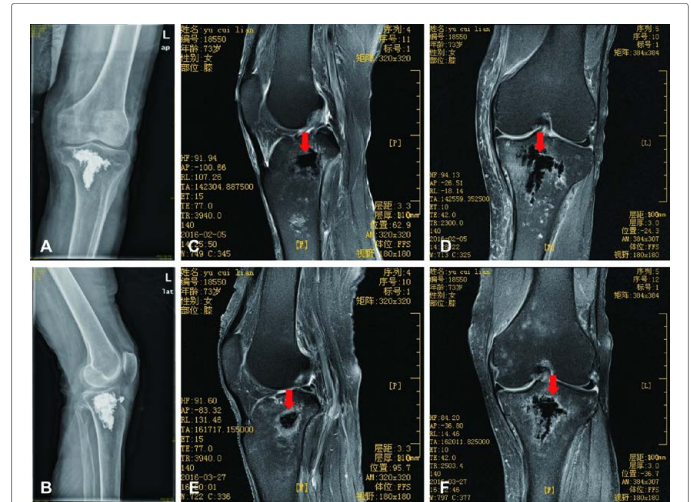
(A and B) X-ray (The lateral view, anterior and posterior view) shows the polymethyl methacrylate is localized in the center of BME. C and D: The lateral view (C) and anterior and posterior view (D) of MRI shows bone marrow edema is disappeared, and the polymethyl methacrylate (read arrowhead) is shown in deep dark as demonstrated by T1 weighted MRI. (E and F) The lateral view (E) and anterior and posterior view (F) of MRI shows no any sign of bone marrow edema. The polymethyl methacrylate (read arrowhead) is existed in deep dark, and some new bone Ingrowth in light dark as demonstrated by T1 weighted MRI.
